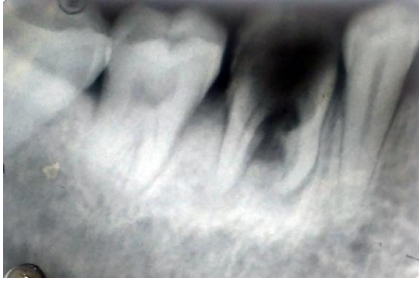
Intra oral periapical radiograph showing fractured root
